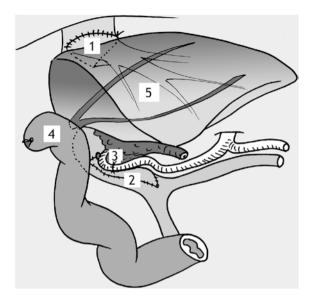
The five key steps for transplantation of a left liver lobe (left lateral segment graft) from either a post-mortem or a living donor: (1) Large triangular-shaped piggy-back implantation onto the vena cava (using the ostia of all three recipient hepatic veins); (2): The whole portal trunk of the recipient is retained until its bifurcation, and the vein is refashioned in the case of hypoplasia (diameter < 5 mm), with an end-to-end porto-portal anastomosis; (3): End-to-end microsurgical arterial anastomosis, between the donor left hepatic artery and a distal site on the recipient hepatic arterial system; (4): Bilio-jejunal drainage with straight positioning of the Roux-en-Y jejunal loop; (5): Medial positioning of the graft followed by US Doppler check of the vascularization at end of operation, before closing the abdomen
